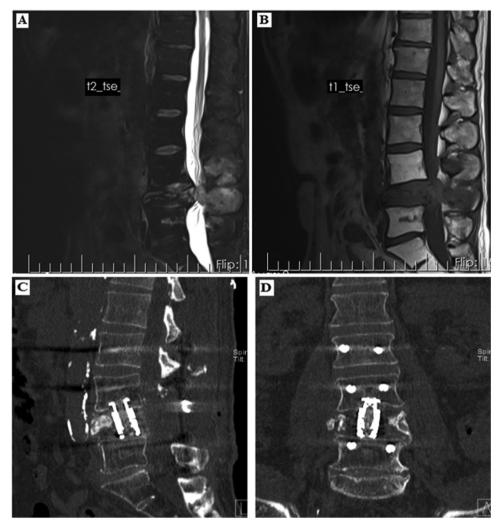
Prostate cancer patient presenting with grade 3 L3 vertebral compression fracture 16 months after SBRT: (A) T2-weighted sagittal section, (B) T1-weighted sagittal section, (C) post-operative sagittal CT section following L3 decompression and instrumentation, (D) post-operative coronal CT section following L3 decompression and instrumentation.
